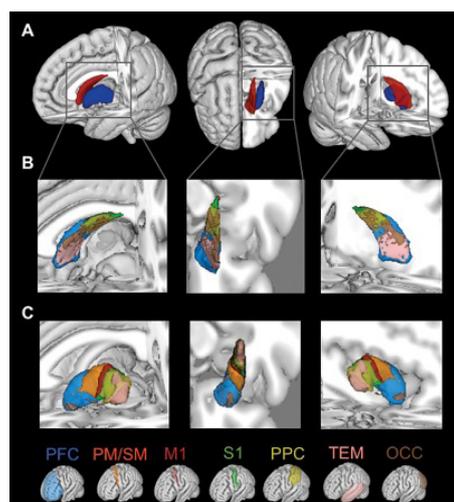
(A) Three-dimensional segmentation of the human caudate (red) and putamen (blue). Organisation of cortical connections within the (B) caudate and (C) putamen. The cortical target regions of interest corresponding to each colour in (B & C) are shown at bottom. All segmentations are overlaid on the standard space MNI152 T1 weighted 1mm structural MR image. PF, Prefrontal; PM, Premotor; M1, Primary motor; S1, Somatosensory; PP, Posterior parietal; OCC, Occipital; TEM, Temporal
